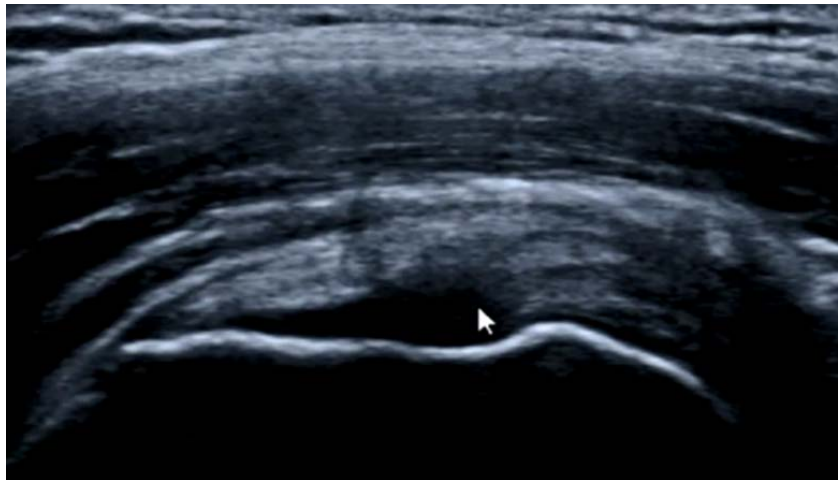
A 28-year-old patient, road traffic accident. Trauma to the right shoulder. Pain with limitation of right shoulder movement. Ultrasound at 14 days. High-frequency probe, coronal section. Evidence of an anechogenic defect of the deep aspect of the supraspinatus (white arrow). Source: CHUYO IMR Department.
